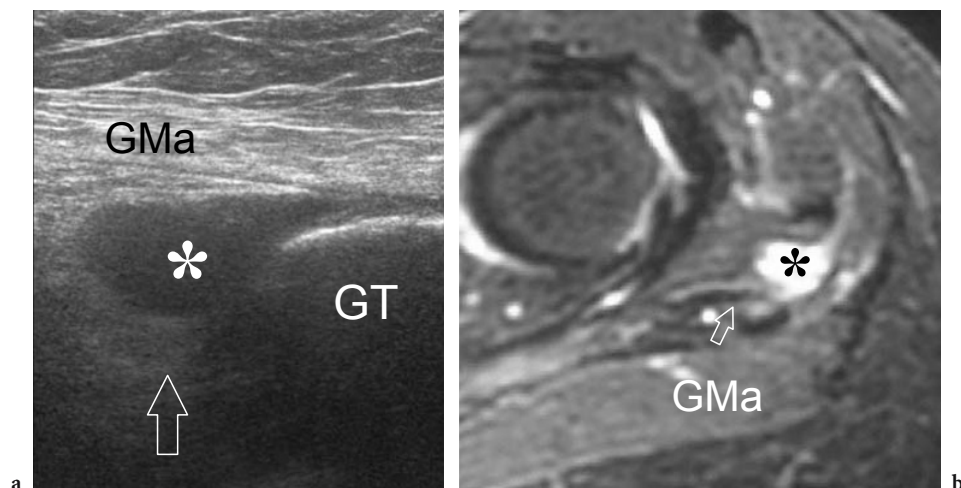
Trochanteric bursitis. a Coronal 12–5 MHz US image shows a well-defined oval-shaped anechoic fluid collection (*asterisk*) located between the deep aspect of the gluteus maximus muscle (*GMa*), the posterosuperior aspect of the greater trochanter (*GT*) and the lateral aspect of the gluteus medius tendon (*void arrow*). b Transverse fast-STIR MR image confirms fluid distension of the bursa consistent with trochanteric bursitis.
